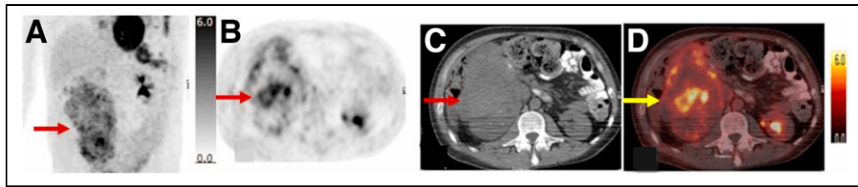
A 25-y-old man with multiple recurrent osteosarcoma and large right renal metastasis (arrows; SUV_{max} , 7.1): anterior maximum-intensity-projection view (A); ^{18}F -FDG PET axial emission image (B), corresponding axial CT image from attenuation correction lesion localization CT (C), and PET/CT image (D).
